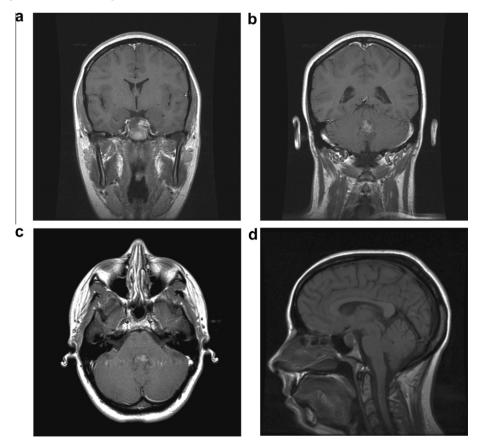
(a,b) Coronal and (c) axial T1-weighted gadolinium enhanced MRI through the sella (a) and 4th ventricle (b,c) demonstrating the sellar and 4th ventricular tumors. (d) Sagittal MR without gadolinium demonstrating both lesions.
